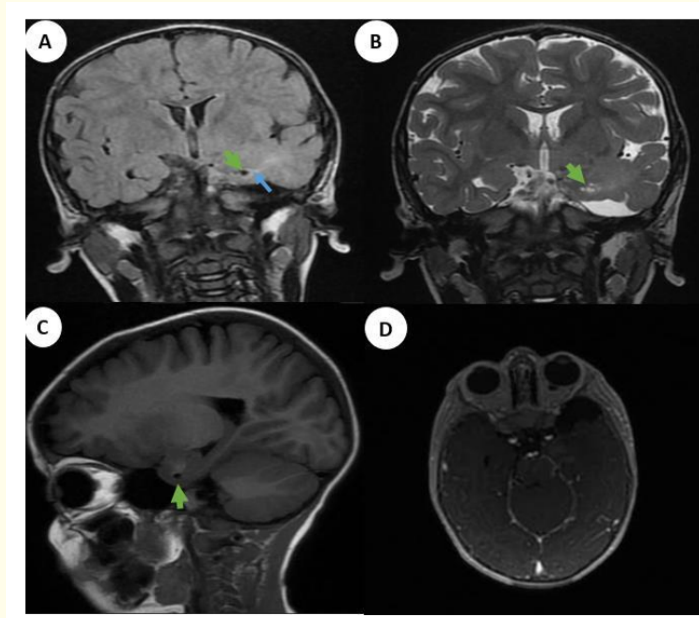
Brain MRI cross-sectional images: coronal FLAIR (A), coronal T2 (B), sagittal FLAIR (C) and axial T1 with PDC injection (D) showing a multimicrocystic aspect in T2 hypersignal, FLAIR hypointense realizing the “soap bubble” aspect (green arrow), with a hyperintense peripheral corona in FLAIR giving a “Bright rim sign” (blue arrow), without enhancement after PDC injection (D), nor peri-lesional edema or mass effect.
